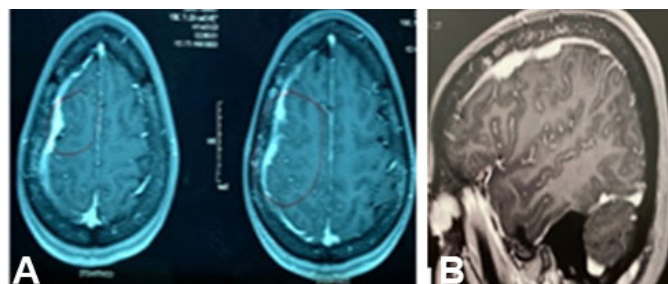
Magnetic resonance imaging showing an 8-mm hyperintense juxtacortical FLAIR lesion associated with T1 hypointensity, without gadolinium enhancement, oval, and extra-axial, at the base of the left parietal-occipital groove and isointense in T2 with tail signal, compatible with plaque meningioma.
